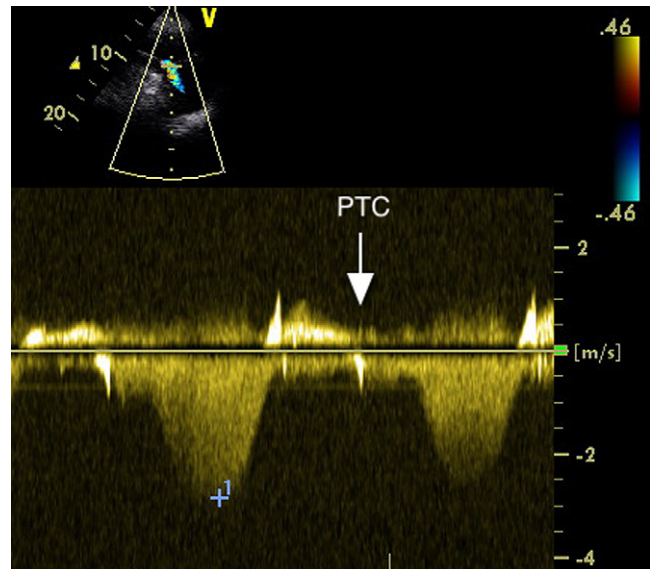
Continuous-wave Doppler through the tricuspid valve obtained by transthoracic echocardiography demonstrates premature closure of the tricuspid valve (PTC).
